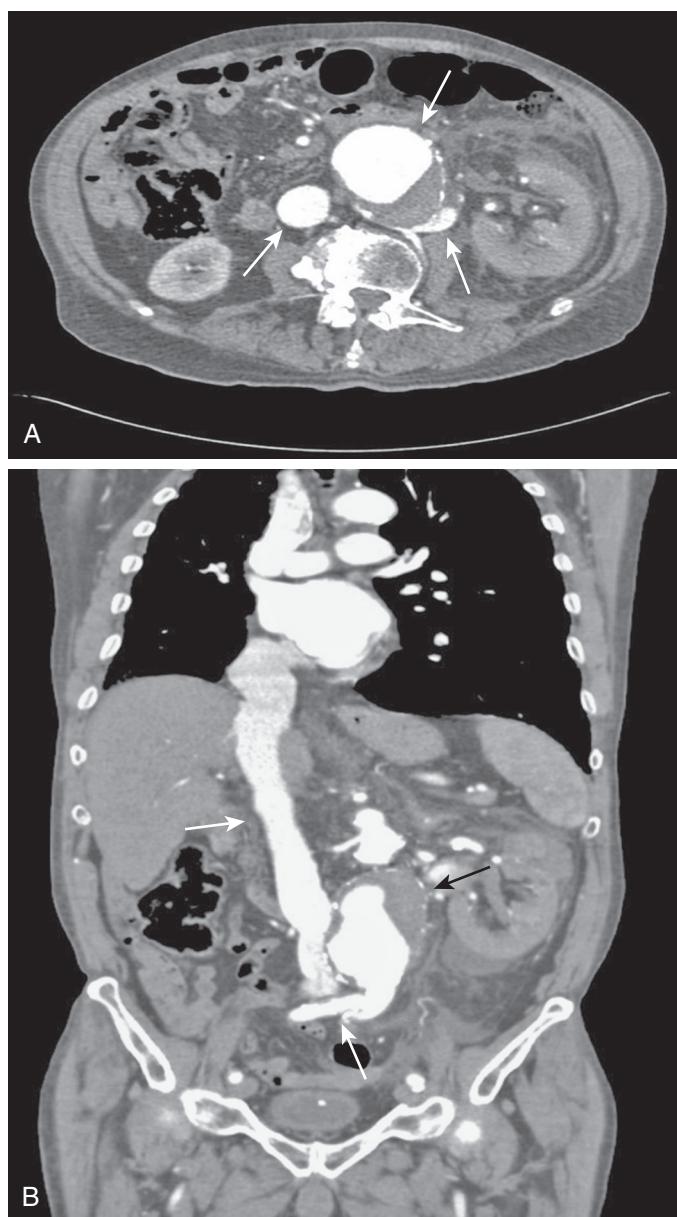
(A) Axial CT scan demonstrating an aortorenal arteriovenous fistula. Contrast material is present in the abdominal aortic aneurysm (top arrow), inferior vena cava (left arrow), and retro-aortic left renal and lumbar veins (right arrow). (B) Sagittal reconstruction of the CT scan in (A) showing contrast material in the aneurysm (black arrow), inferior vena cava (top white arrow), and retro-aortic left renal and lumbar veins (bottom white arrow).
